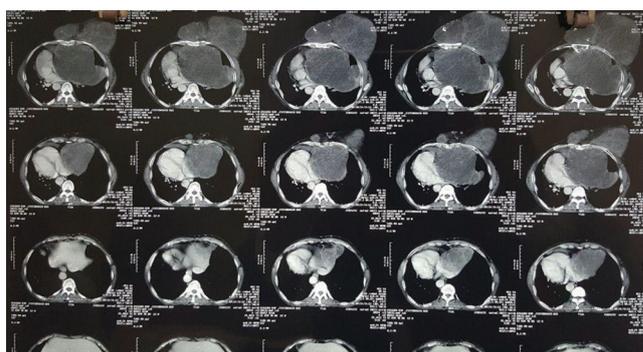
CT Scan showing the extension of chondrosarcoma
